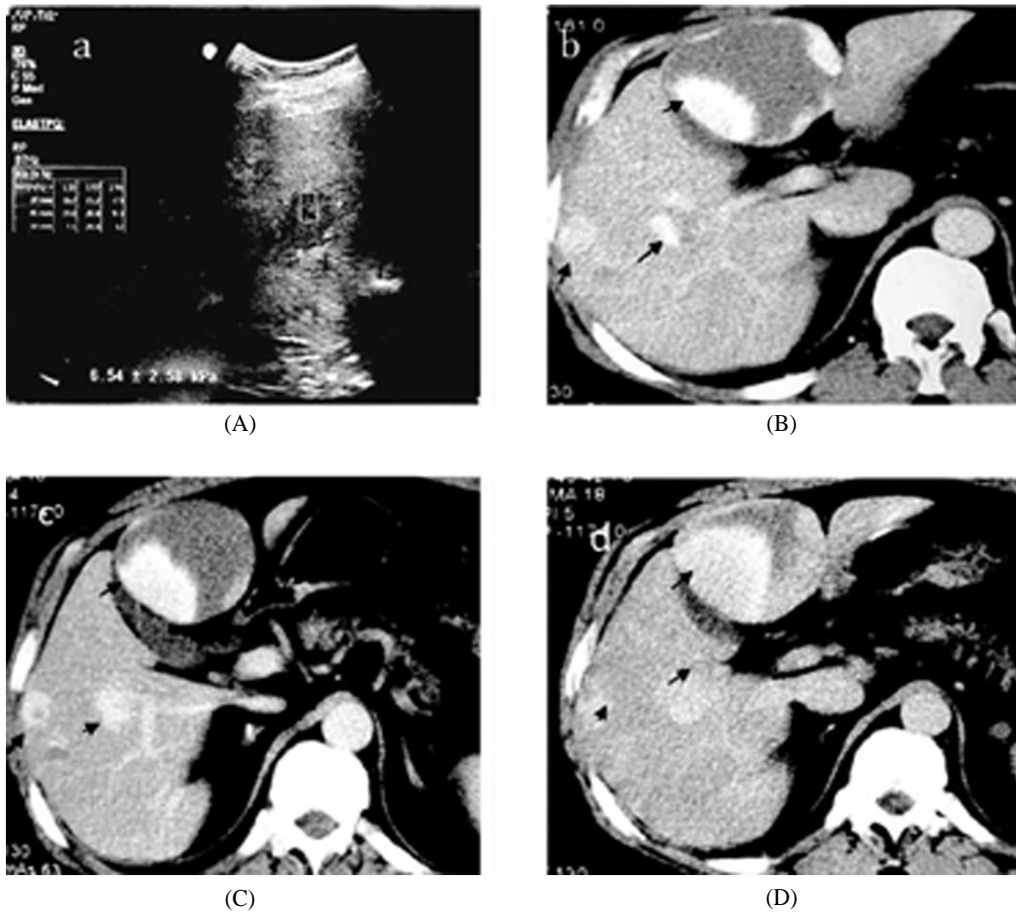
Atypical hemangioma. 52 year old male, coming for follow-up of multiple variable sized hypoechoic focal lesion seen at segments IVa and V. (A) B-mode shows a well-defined hypoechoic focal lesion with SWE mean stiffness value (6 ± 2 kpa). (B-C-D) Axial Triphasic CT, in the arterial, portal and delayed phases, (B, C & D), respectively, showing multiple hepatic focal lesions at segments IVa (the largest) and V, the arterial phase (B), Displays peripheral nodular contrast uptake, while portal and delayed phases (C-D), Display progression of the contrast uptake.
